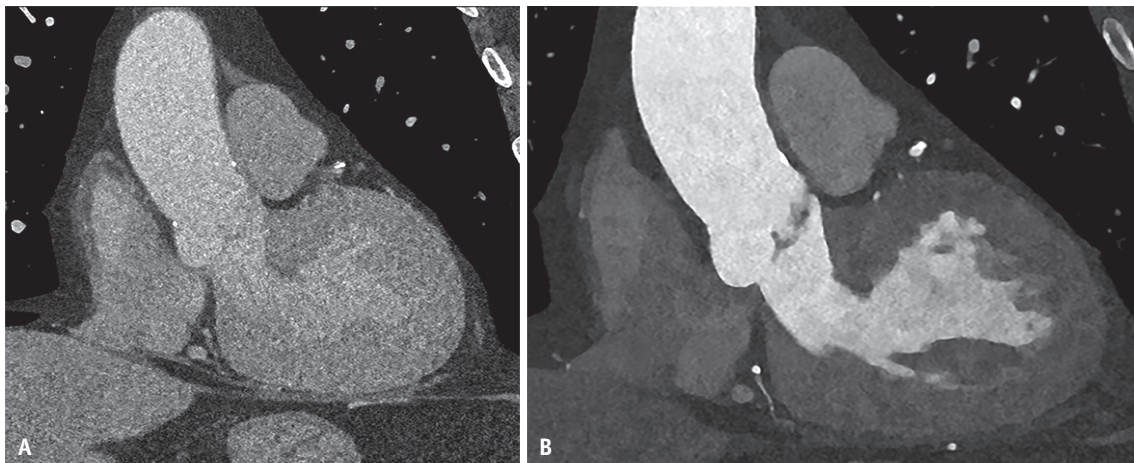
Salvage of suboptimally enhanced CTA using multienergy technique. A: Coronal oblique CTA from photon-counting CT in a 75-year-old male shows suboptimal aortic opacification (mean, 191 HU) due to contrast extravasation during the scan. B: Coronal oblique 50-keV image in the same patient shows improved iodine signal (mean, 450 HU). Low-keV virtual monoenergetic image enhances iodine conspicuity, allowing for a reduced contrast dose and salvaging suboptimally enhanced studies. CTA = CT angiography, HU = Hounsfield unit
